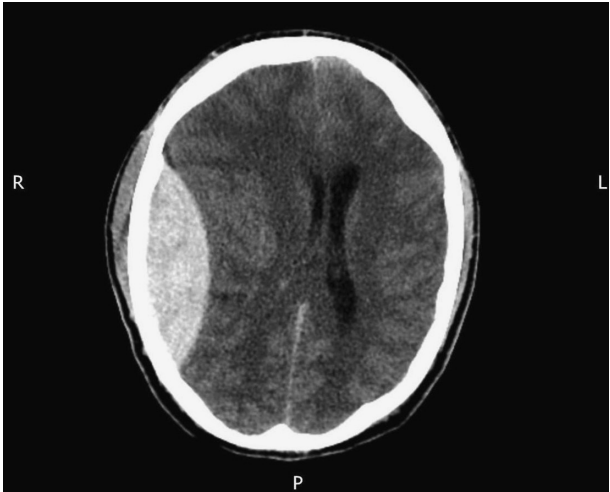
CT of acute right extradural haematoma with associated midline shift.
